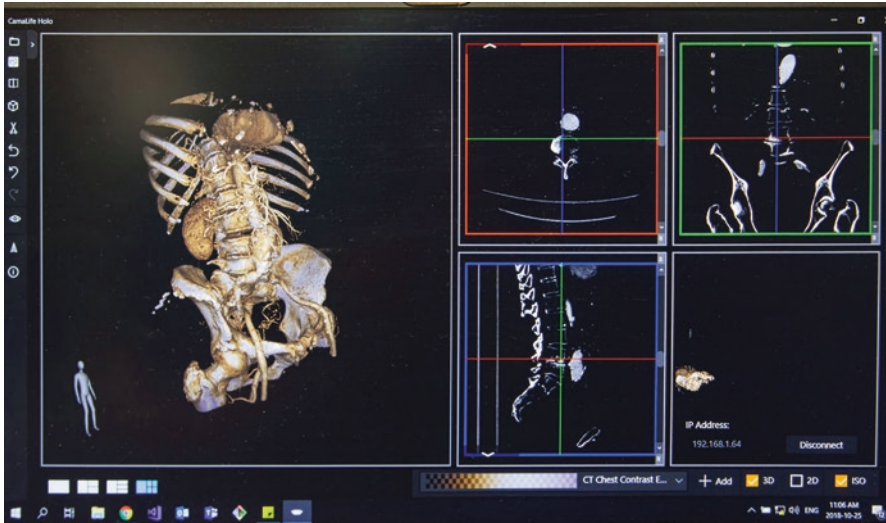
Process of rendering CT scans to hologram. Photo: Tomasz Jędrzejewski, Medical University of Warsaw press office
